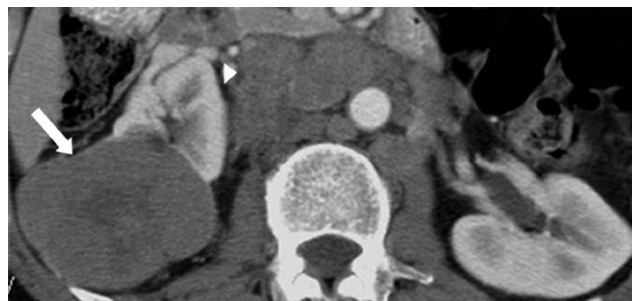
Hereditary leiomyomatosis RCC syndrome. Axial contrast-enhanced CT in the nephrographic phase shows a large, exophytic, papillary RCC (arrow) arising from the posterior cortex of the right kidney. Note the extensive retroperitoneal lymphadenopathy (arrowhead).
